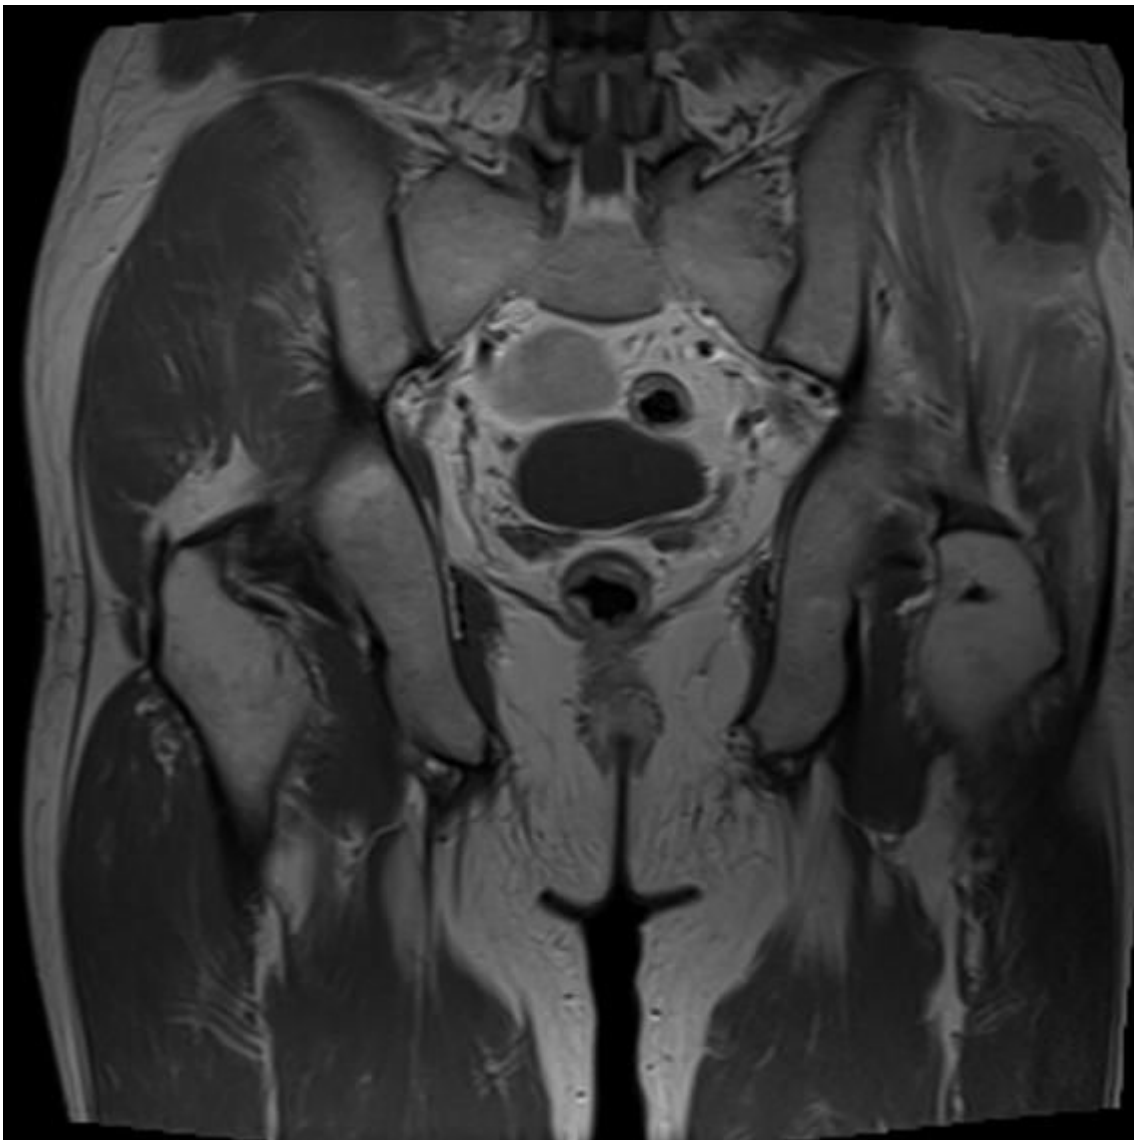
Metastatic lesion in pelvic MRI
